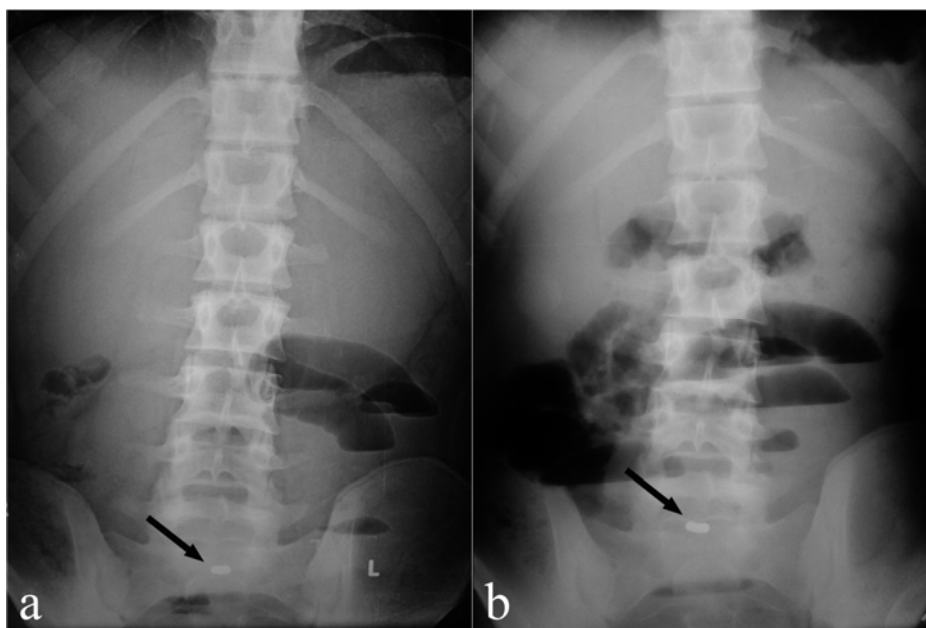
Abdominal radiography performed: a) on admittance showing a several air-fluid levels and foreign body (black arrow); b) after several hours showing a radiographic signs of small bowel obstruction and foreign body in an unchanged position (black arrow).
